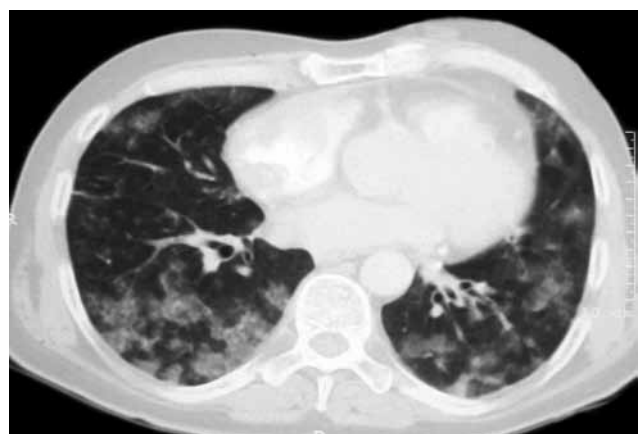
The thoracic computed tomography at admission.
